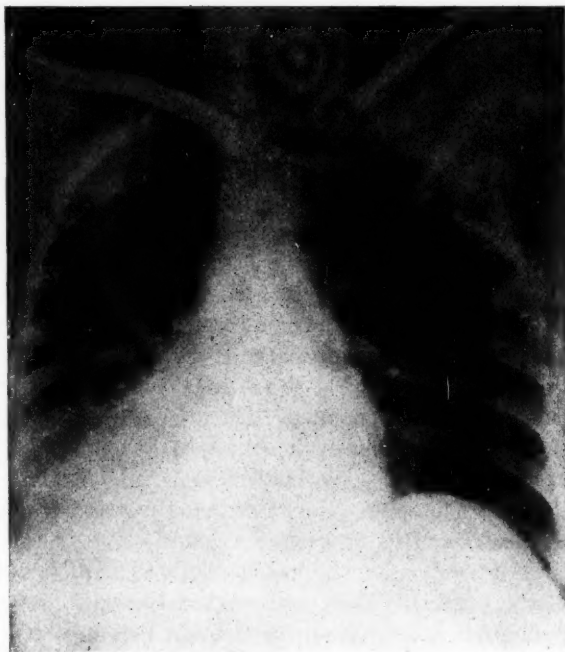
Case II. Roentgenogram taken after the withdrawal of 1680 c.c. of pleural fluid.
